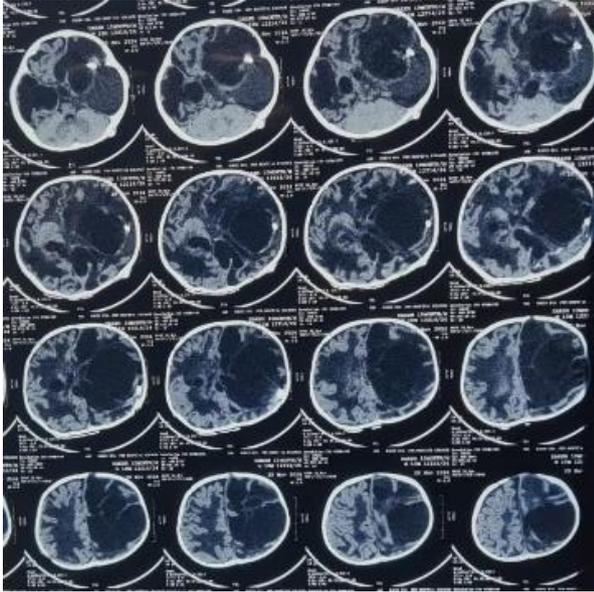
Computed tomography showing ventricular end in left lateral ventricle with no ventriculomegaly on right side.
